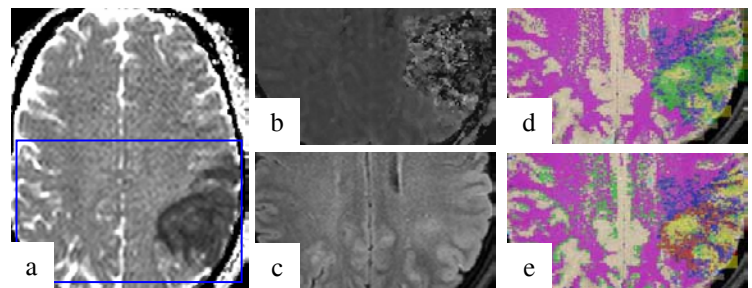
Alphabetically: ADC, MTT, FLAIR, classification using the classes from Table 1 only, and using the additional classes of Table 2.
